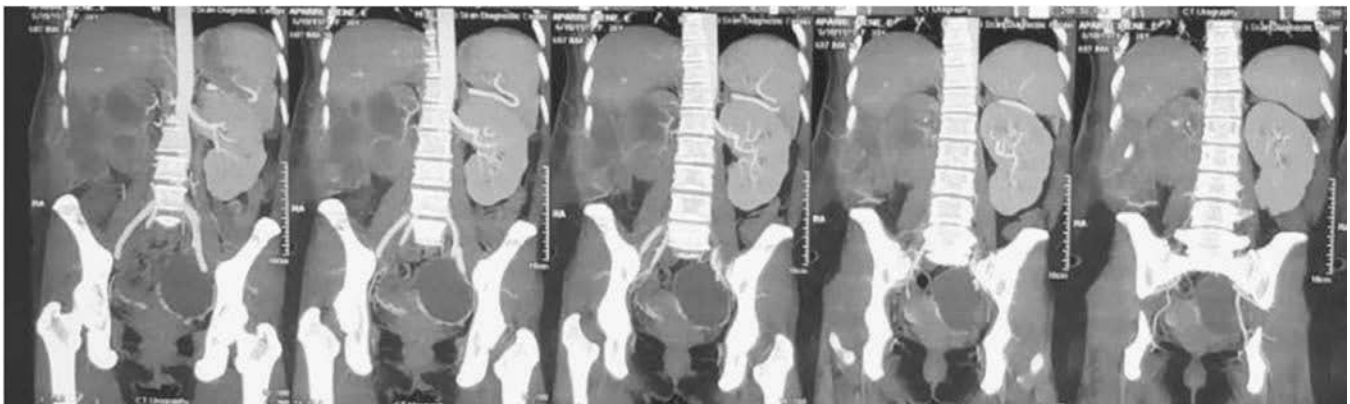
Coronal images of the CT scan showing perinephric abscess with no evidence of obstruction.
